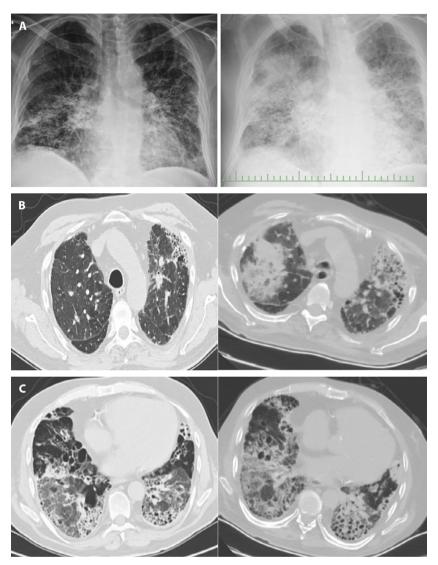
Posteroanterior chest radiography (A) of Chest-X ray and axial-thin section thorax CT images (B, C) were shown for Case 3 with HP. On the left side, radiological images show before the Covid-19 pandemic, and on the right-side radiological images show during Covid-19 pneumonia. Reticulation, ground-glass opacities, and honeycombing were seen on the left side before Covid-19 pneumonia. Increased ground-glass opacities on the left upper lobe, new consolidation on the right upper lobe, and air trapping in the bilateral lower lobes were shown in Covid-19 pneumonia.
